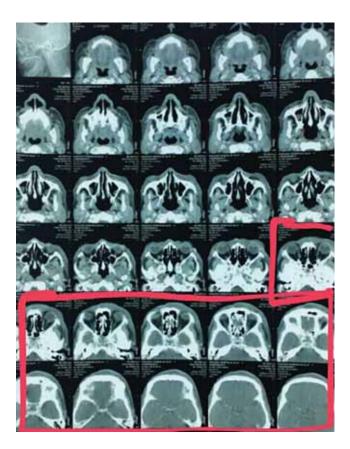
Facial CT scan: thickening with signs of enhancement by contrast on superficial plans/soft tissues of the left periorbital region, extending to the ipsilateral frontal region. Compatible with periorbital cellulite
